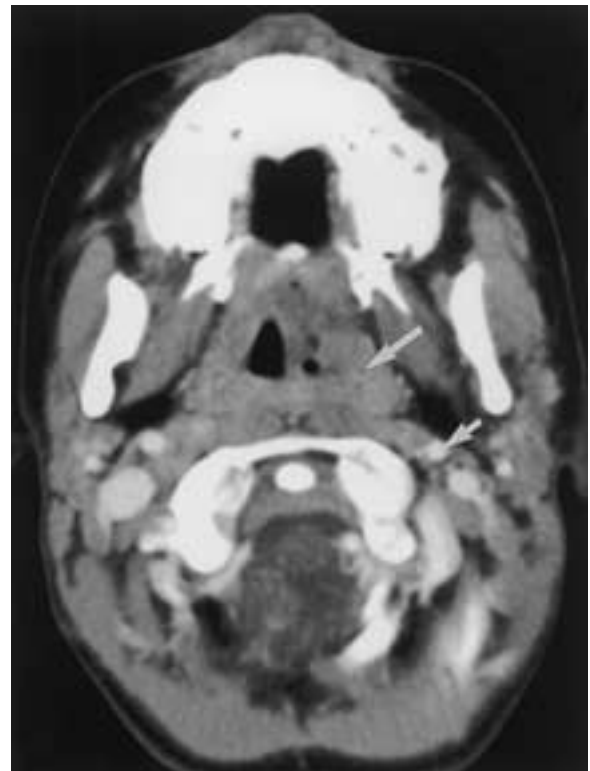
Oropharyngeal trauma in a toddler who fell with a toothbrush in his mouth. Contrast-enhanced CT reveals asymmetric thickening of the left pharyngeal mucosa and distortion of the airway but no extravasation of air (*long arrow*). The left internal carotid artery appears slightly smaller than the right (*short arrow*).
